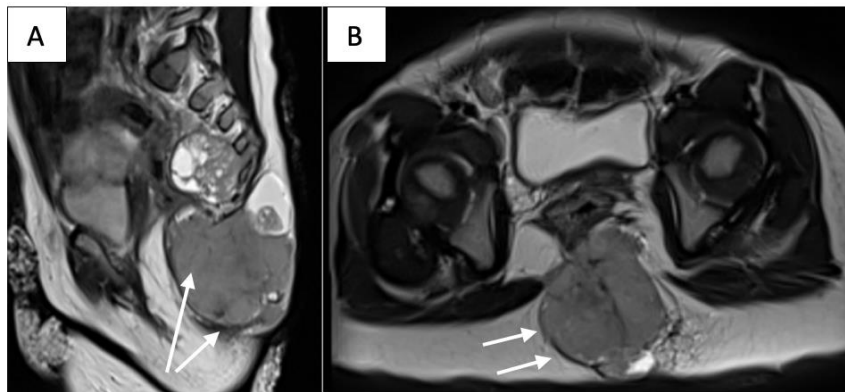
Initial MRI: Sagittal (A) and Axial (B) T2-weighted images showing a large heterogeneous mass (arrows) extending from the subcutaneous sacrococcygeal region through a bony defect into the presacral space, displacing the rectum and uterus
